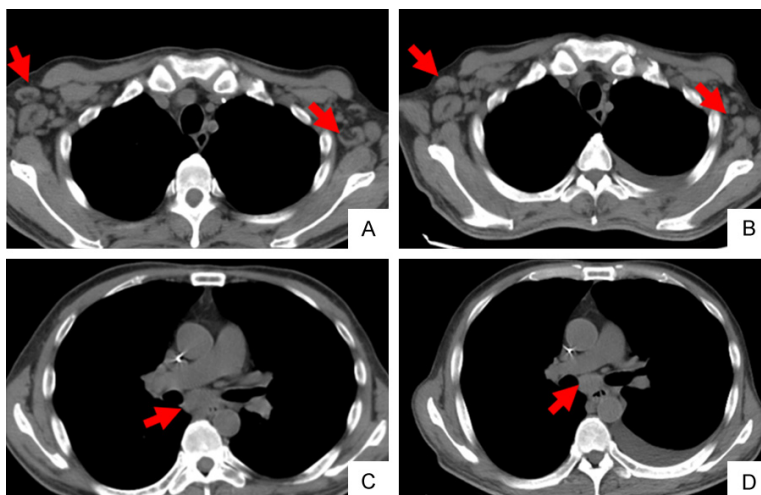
Lung CT image of the patient 2. A, C. Multiple enlarged lymph nodes in the mediastinum, bilateral supraclavicular area and bilateral axilla; B, D. The CT scans of the patient who was automatically discharged from the hospital. It shows multiple enlarged lymph nodes in the mediastinum, bilateral supraclavicular area and bilateral axilla.
